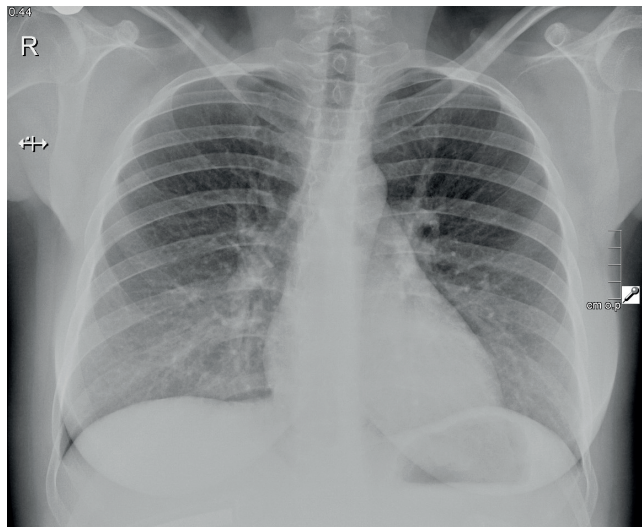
Minimally displaced 10th rib fracture is showed at X-ray graphy
